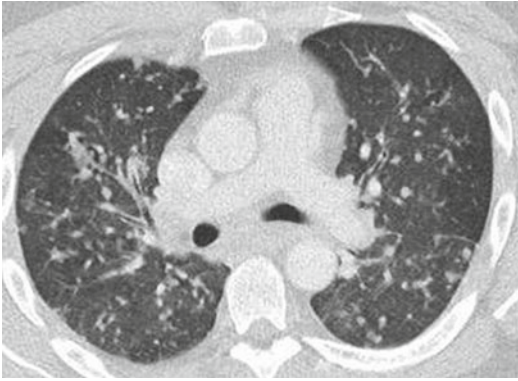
Nodular infiltrate in a patient treated for lung cancer. This 61-year-old patient was treated with Iressa (gefitinib) for bronchioloalveolar carcinoma. The predominant CT pattern is random nodules. Understanding that this is not a typical appearance of chemotherapy-related lung injury allows the radiologist to offer an alternative explanation for the patient's shortness of breath. In this case, the diagnosis was granulomatous infection from histoplasmosis
